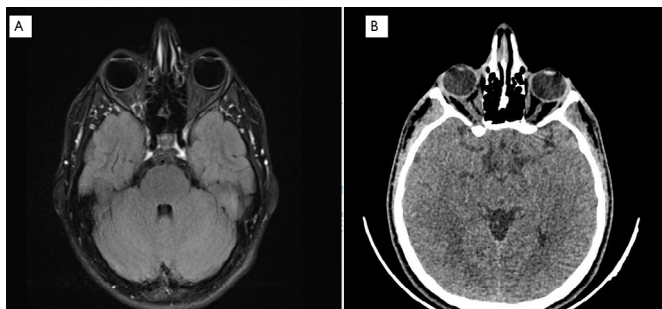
Contrast-enhanced orbital MRI, axial T1-weighted with fat suppression. The image reveals an anomalous region situated slightly lateral to the proximal 1/3 of the optic nerve, positioned 13 mm posterior to the disc level in the right orbit. Unfortunately, the precise assessment of its size and intensity is impeded by a magnetic susceptibility artifact, as indicated in the description. Figure 2B. Axial CT scan: asymmetric thickening and coarse densities in the central right medial rectus
